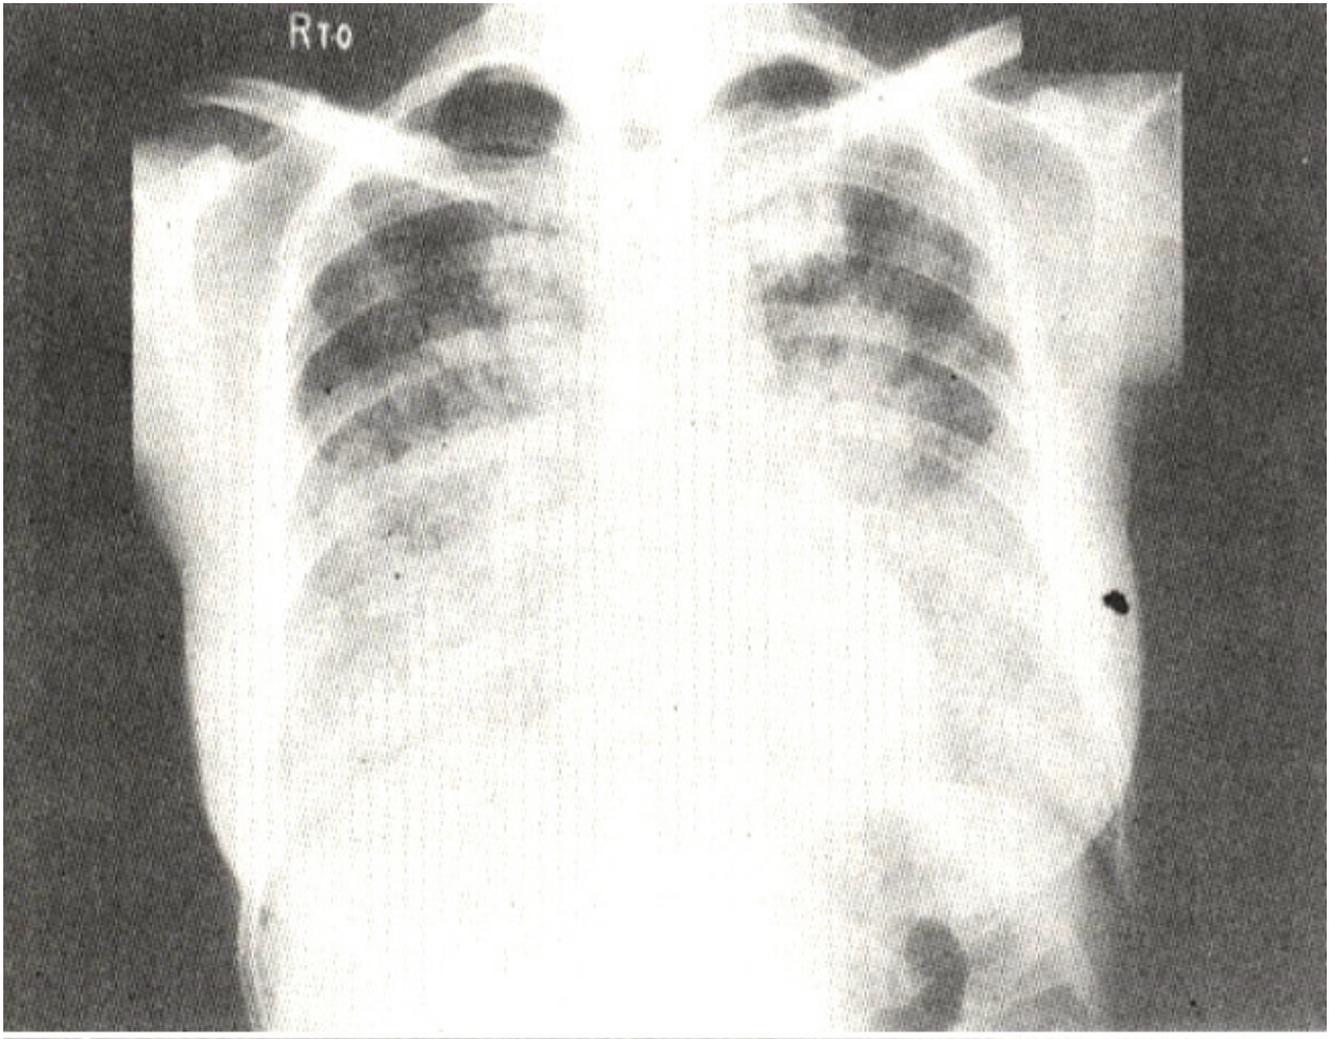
PA Radiograph of chest.
